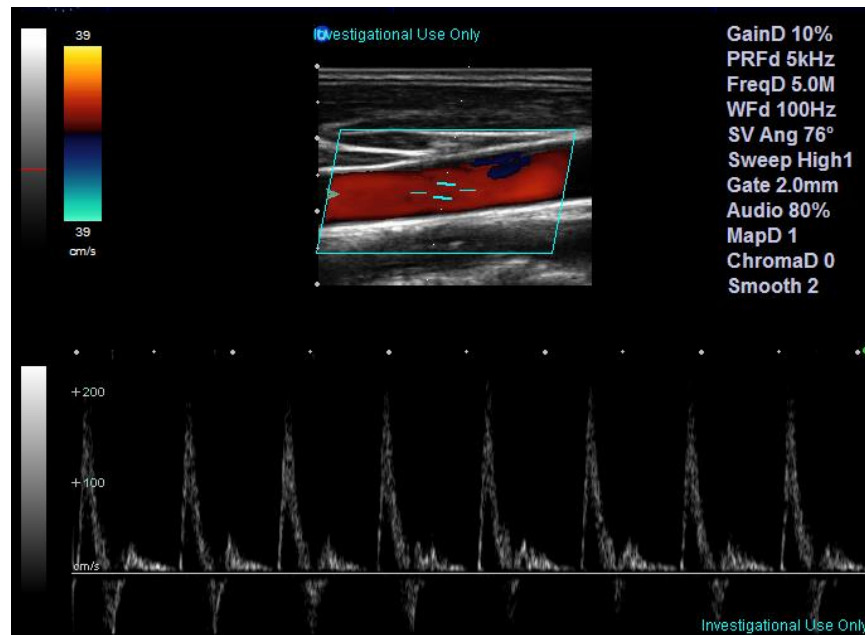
Triplex mode sonography combines B-Mode ultrasound with pulsed-wave (PW) Doppler and color flow imaging in order to image arterial structure and blood flow simultaneously. The light blue trapezoid in the image represents the CFI area, while the light blue lines in the lumen of the artery represents the sample gate at which the PW Doppler flow spectrum is measured.
